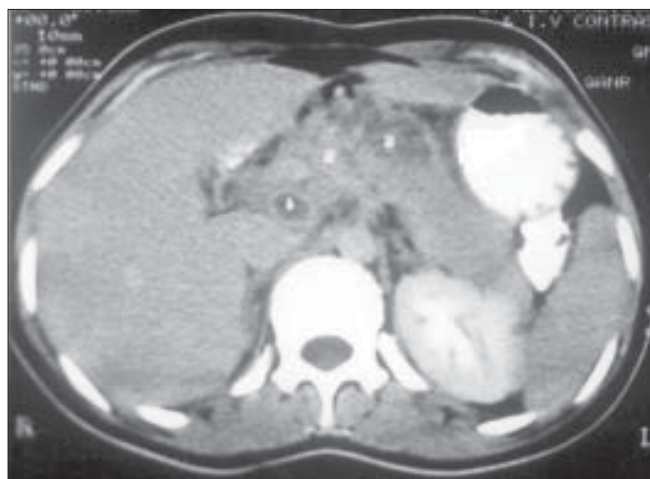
A computed tomography scan of the abdomen showing a tubercular mass in the region of the pancreas, contiguous with the head and body of the pancreas
